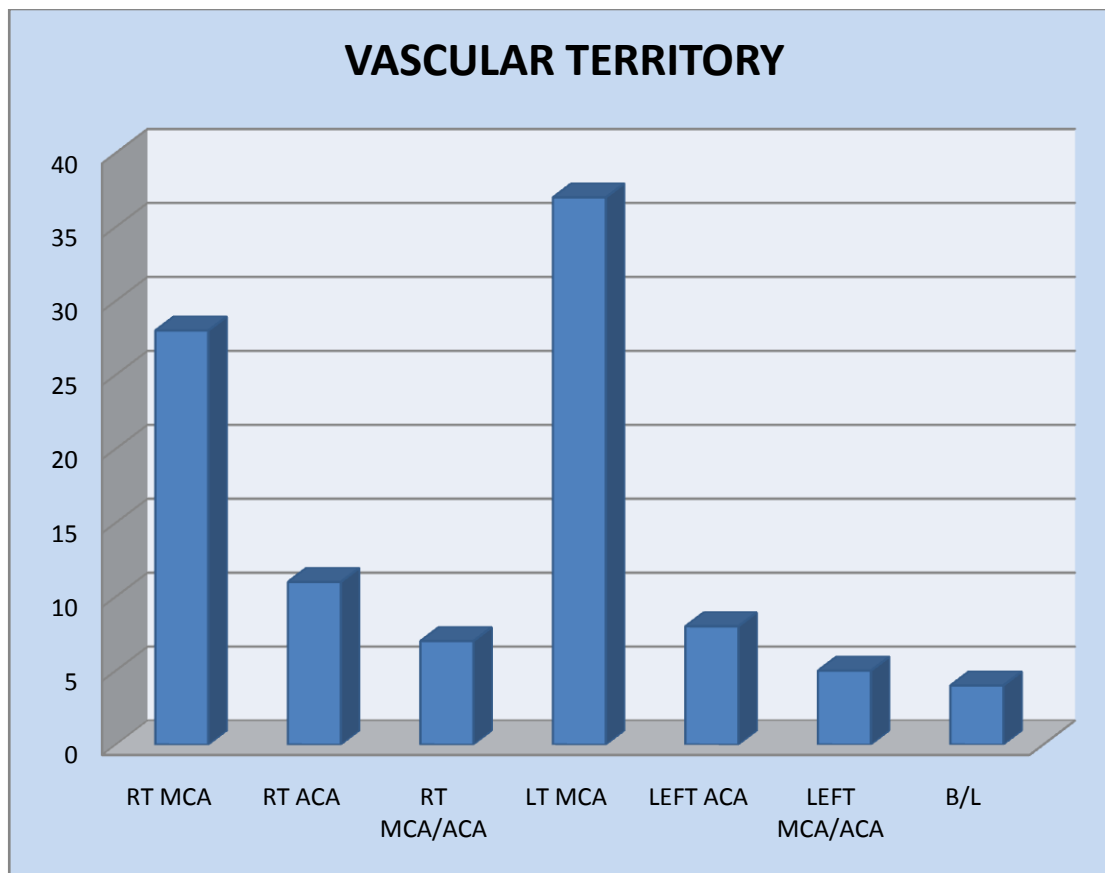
MRI Scan Findings In Stroke Patients.
